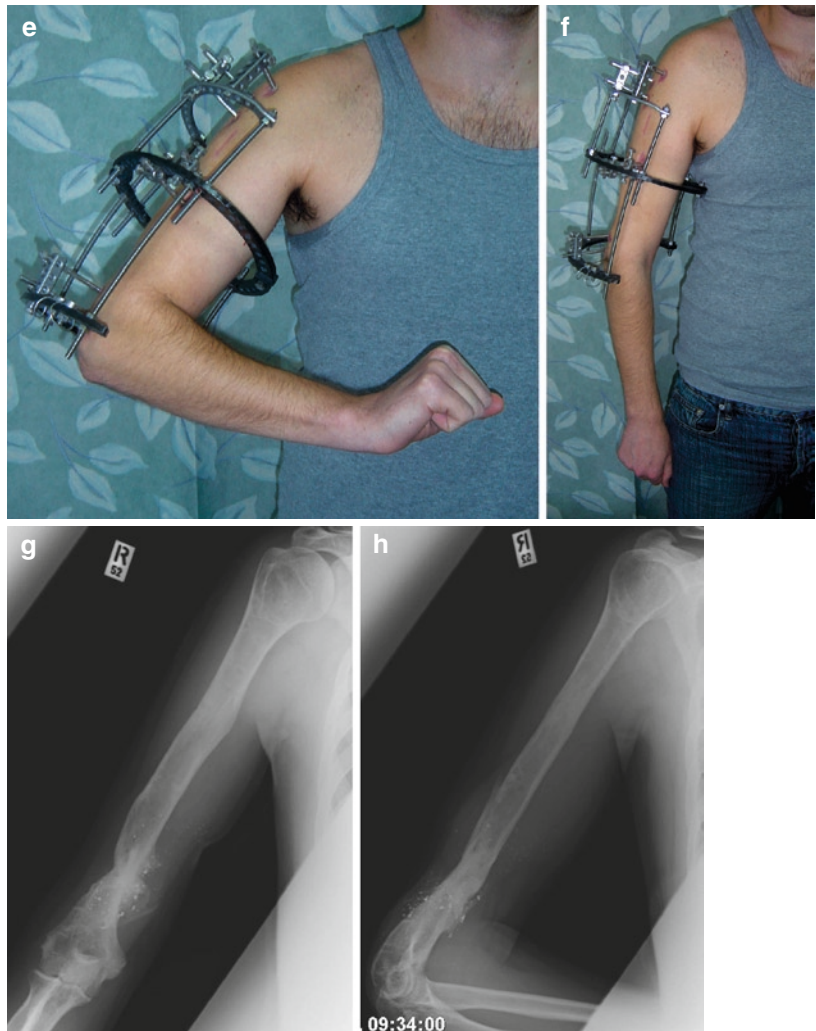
A 23-year-old male with open right humeral fracture Gustilo-Andersen type IIIB with bone and soft tissue loss resulting from blast injury by antitank rocket. (a) Clinical appearance of right arm after primary debridement and skeletal stabilization using tubular unilateral external fixation frame. (b) Control postoperative x-ray of the right arm demonstrates severe bone loss, multiple small metal foreign bodies at fracture zone. (c) After repeated debridement procedure, acute shortening was performed to diminish soft tissue defect. Control radiogram demonstrates contact between proximal and distal bone
